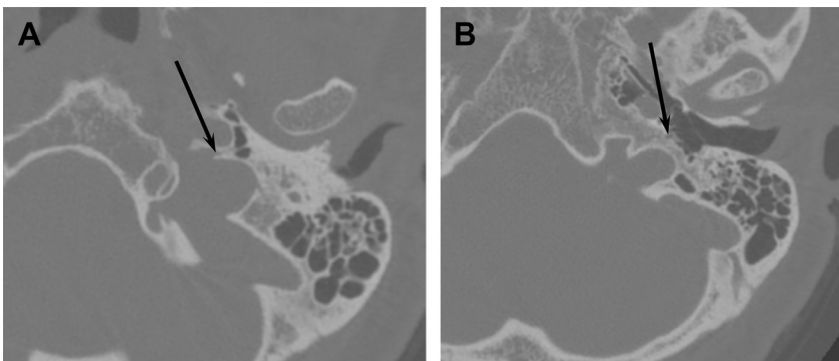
Jacobson nerve. Axial CT images through the temporal bone show (A) inferior aspect of petrosal fossula (*arrow*) in the pars nervosa at site of the origin of Jacobson nerve as it heads toward the middle ear cavity. It is adjacent to the caroticojugular spine at this level. (B) Superior aspect of petrosal fossula (*arrow*) and site of origin of normal, nonenlarged inferior tympanic canaliculus, for CN IX branch–Jacobson nerve as it heads into middle ear cavity.
